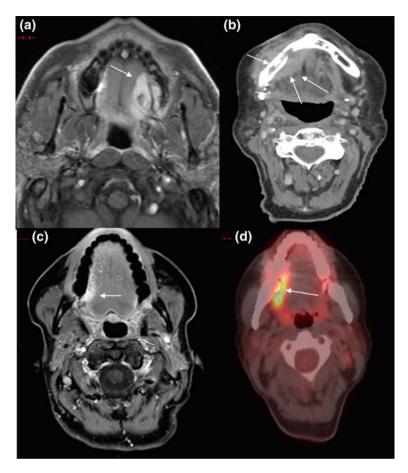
Oral cavity cancers. a Axial T1 post contrast shows left hard palate cancer b Contrast CT shows right floor of mouth cancer with involvement of adjacent mandible and buccal mucosa (*arrow*) c axial T1 post contrast and d PET-CT show right lateral tongue mass. This lesion was masked by dental artifact on the conventional CT neck but easily seen on MRI and PET-CT
